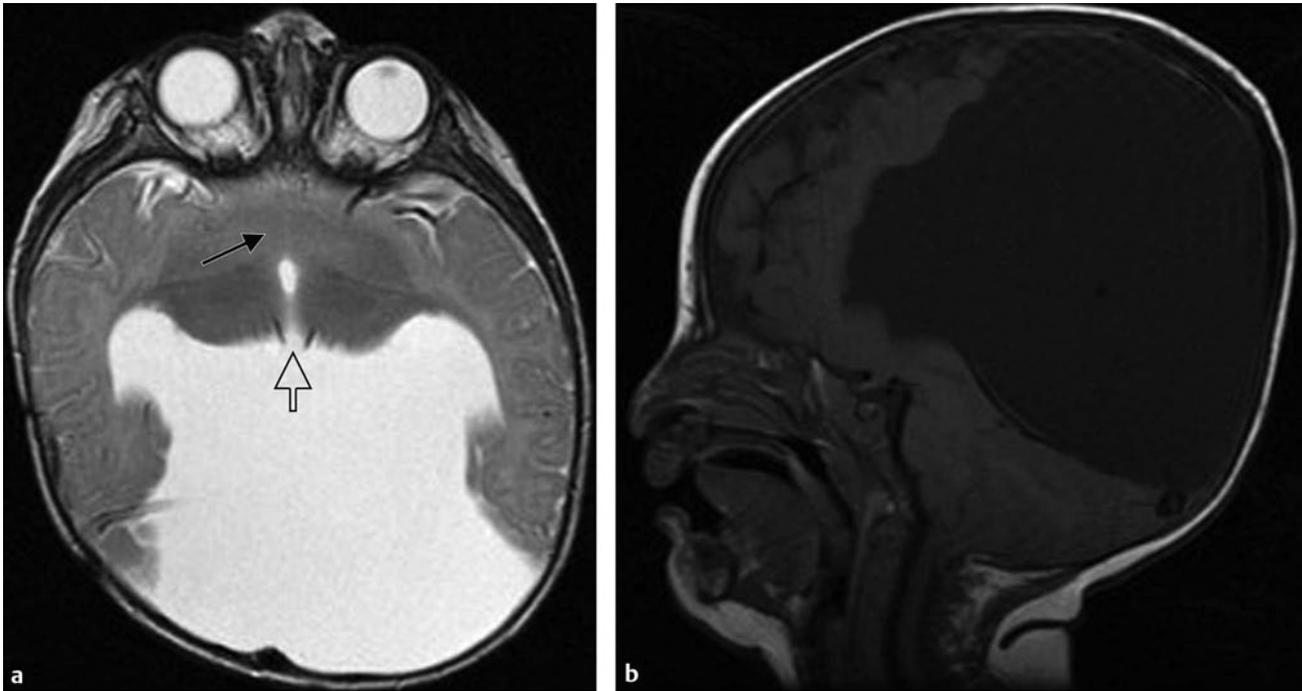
Axial T2-weighted (a) and sagittal T1-weighted (b) magnetic resonance images of a child with alobar holoprosencephaly show fused basal ganglia (arrow) and a monoventricle that opens to a dorsal cyst. The thalami are partially fused (open arrow).
